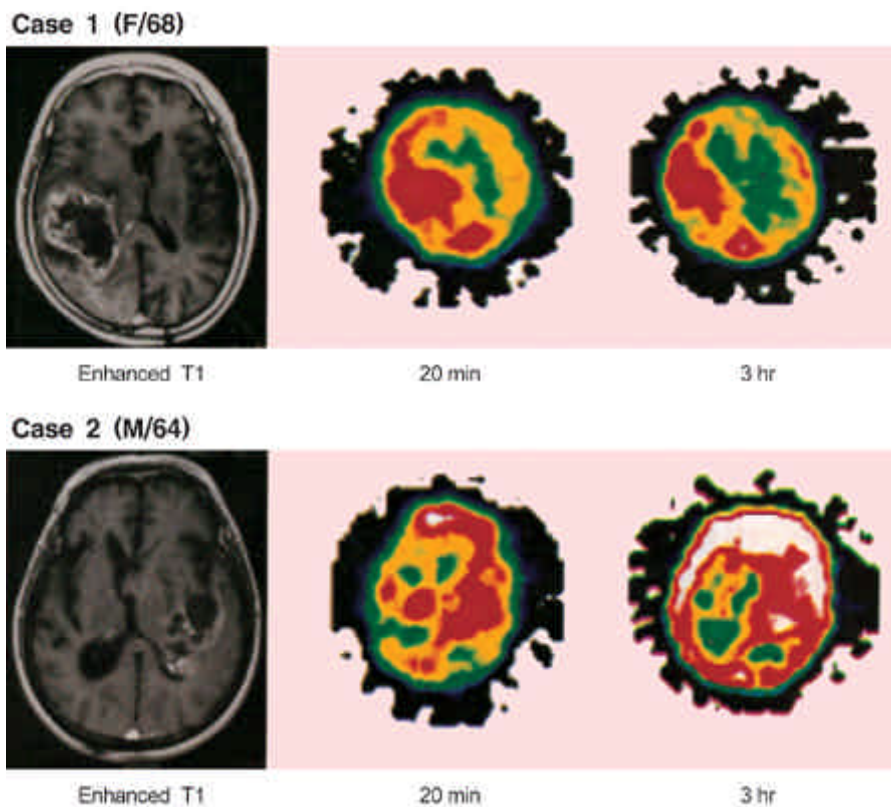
^{99m}Tc-HMPAO SPECT and MRI images.
